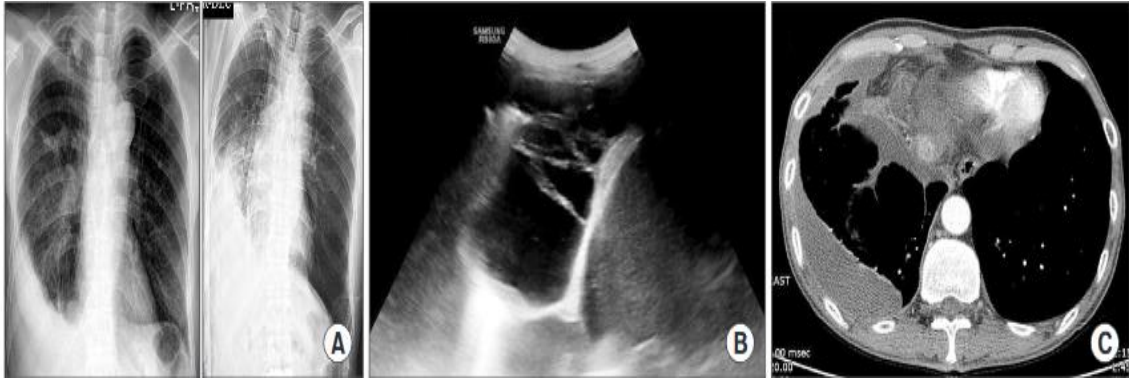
The representative radiographic finding of loculated tuberculous pleural effusion. (A) Chest plain X-ray shows no shifting of pleural fluid on decubitus film, as compared with chest posteroanterior view. (B) Thoracic real-time sonography shows complex septated pleural effusion. (C) Chest computed tomography shows loculated pleural fluid accumulated in nondependent portion
